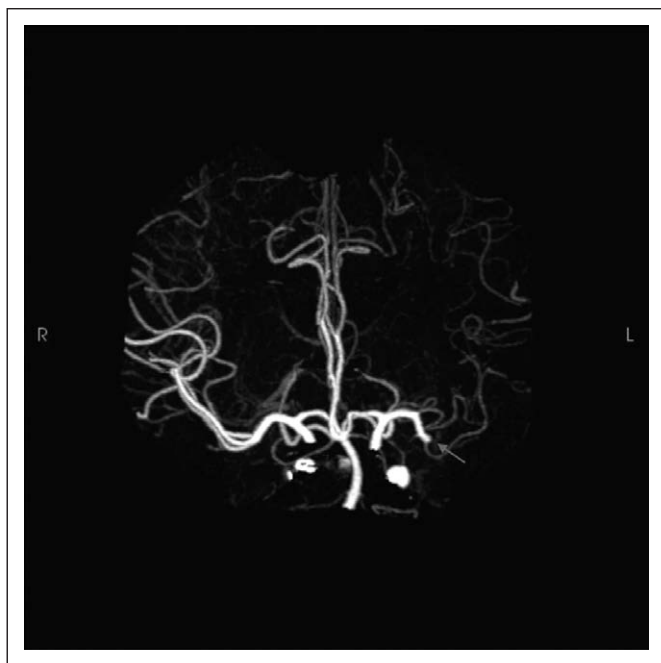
CT-angiography demonstrating an abrupt occlusion of the patient's left middle cerebral artery (arrow). L = left, R = right.
